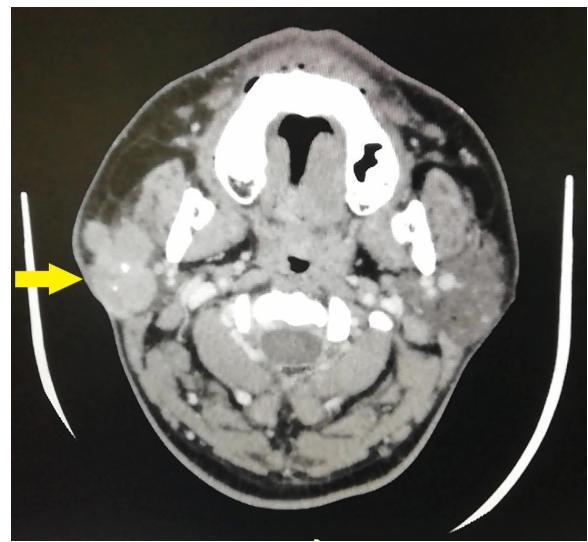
CT neck shows homogeneously enhancing multilobulated mass in superficial lobe of right parotid gland, measuring 4.2cm x 2.7 cm x 4.6cm, with foci of calcification. The mass appears abutting masseter muscle anteriorly, trapezius muscle posteriorly and extending to skin laterally without parapharyngeal extension medially.
